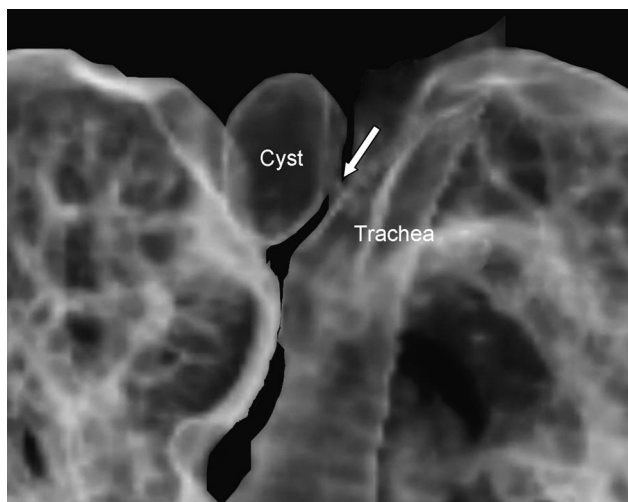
Three-dimensional reconstructive computed tomography image shows a thin-wall cyst posterolateral to the trachea, with obvious connection with the trachea (arrow).
